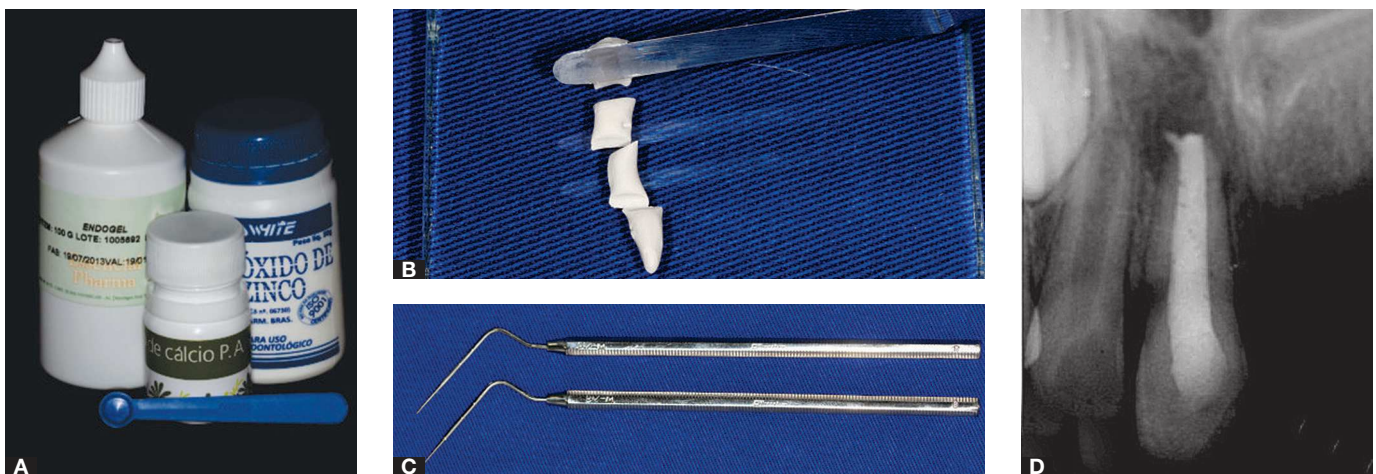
A) Calcium hydroxide P.A., 2% chlorhexidine gel (Endogel) and zinc oxide used as intracanal dressing; B) Paste final consistency; C) Vertical condenser used to insert the intracanal dressing; D) Final radiograph evincing the quality of intracanal dressing insertion.
